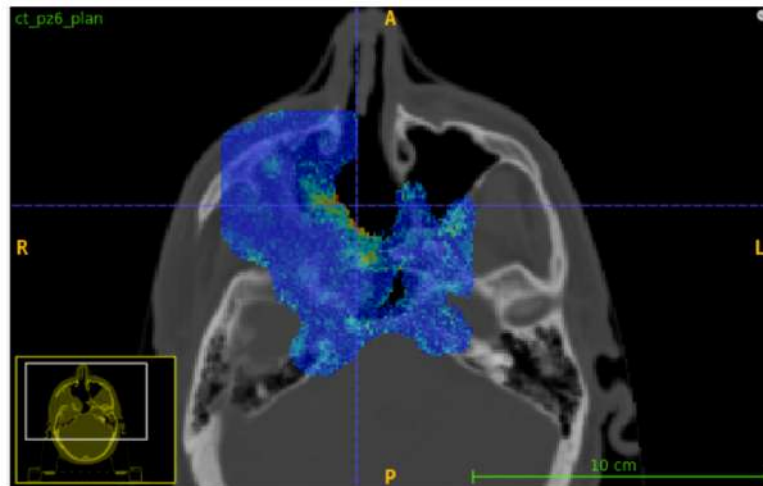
Gamma mode map for  $DD = 20\%$ ,  $DTA = 2$  mm,  $DTH = 0.5\%$  in axial, sagittal and coronal views (from top to bottom), overlaid on the planning CT.
